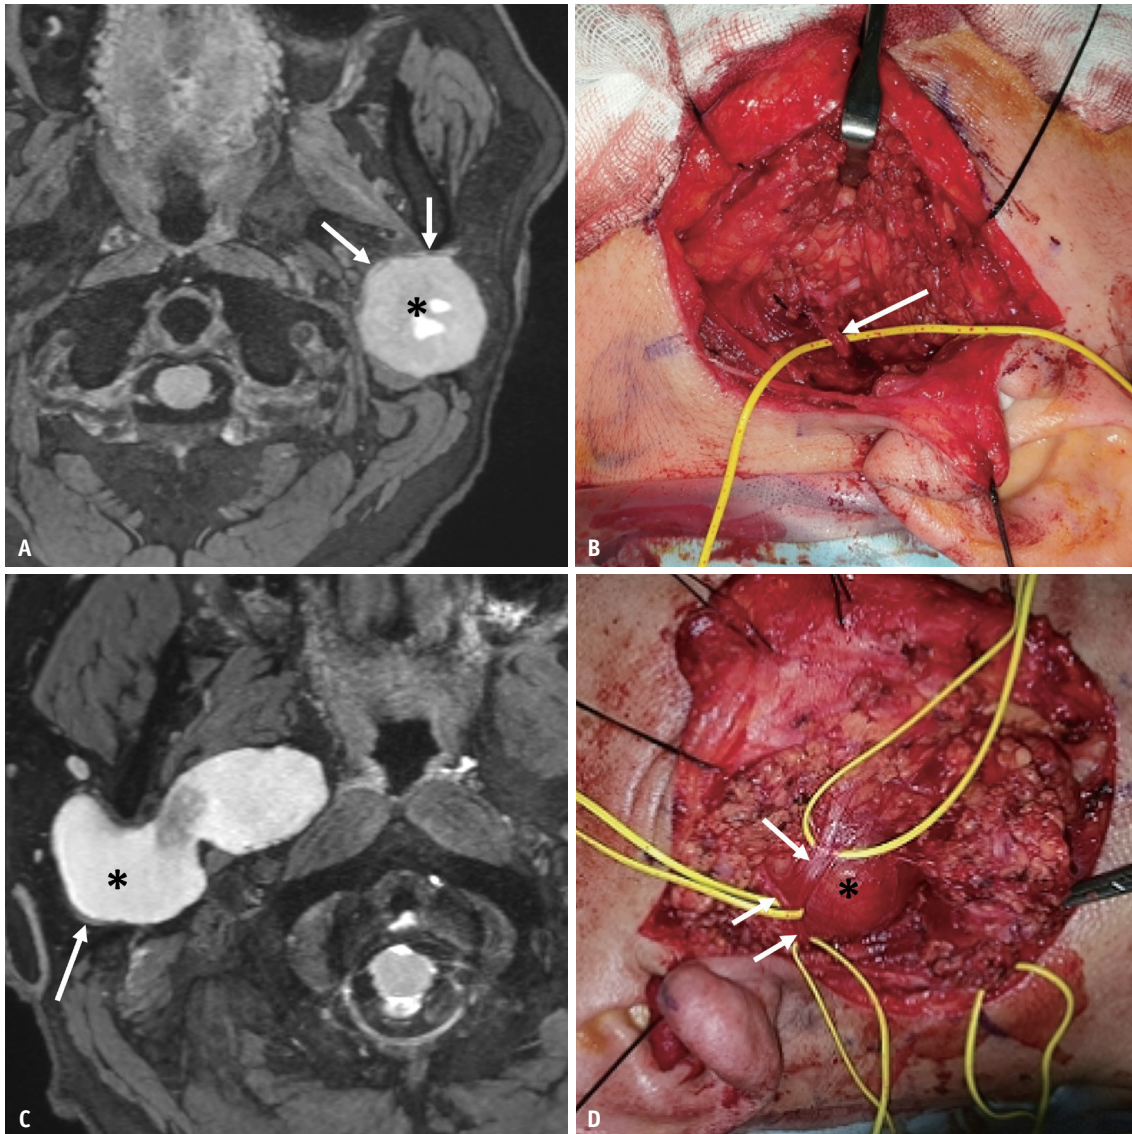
Comparison of 3D-DESS-WE-MRI images and surgical findings. A, B: Superficial-lobe tumor. The left parotid gland tumor (asterisk) is located lateral to the facial nerve (arrows), indicating a superficial-lobe tumor. An intraoperative photograph (B) taken after tumor removal demonstrates the facial nerve (arrow) located deep to the tumor. C, D: Deep-lobe tumor. The tumor in the right parotid gland (asterisk) is located medial to the facial nerve (arrow), indicating a deep-lobe tumor. An intraoperative photograph (D) clearly demonstrates the tumor (asterisk) located deep to the facial nerve (arrows). 3D-DESS-WE-MRI = three-dimensional double-echo steady-state water-excitation sequence magnetic resonance imaging
